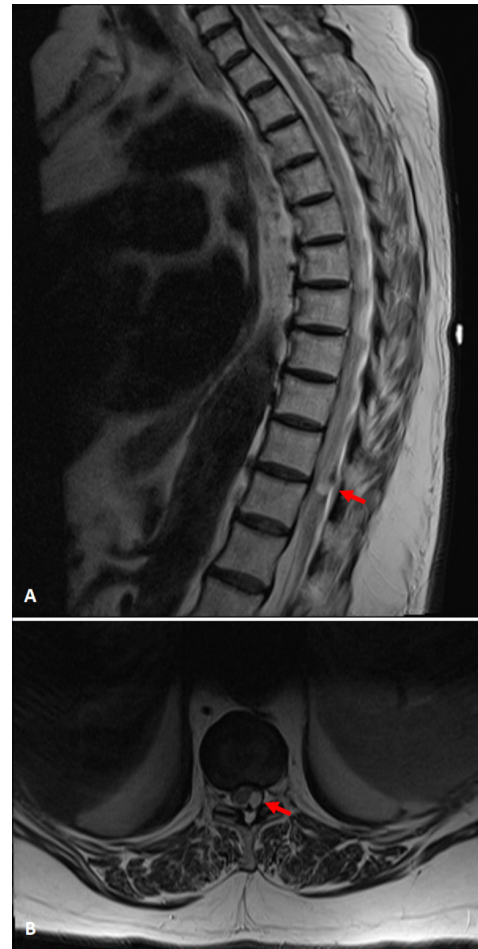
(A-B) Initial MRI. (A) Sagittal and (B) Axial T2-weighted MRI sequence demonstrating the intradural extramedullary lesion (red arrows) at the level of T10-11.
